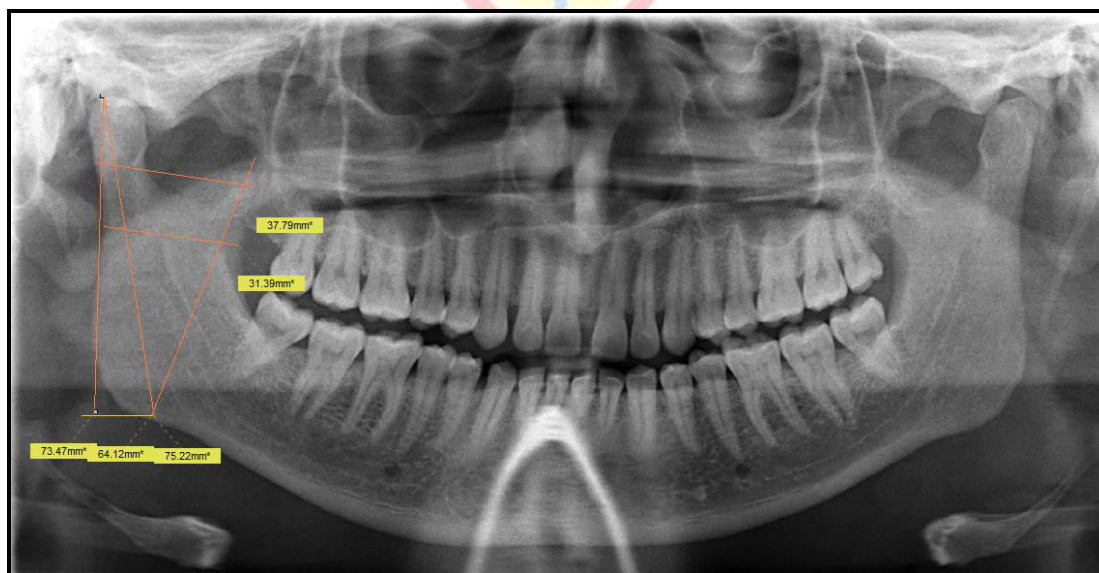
Measurements of mandibular ramus on orthopantomographs
